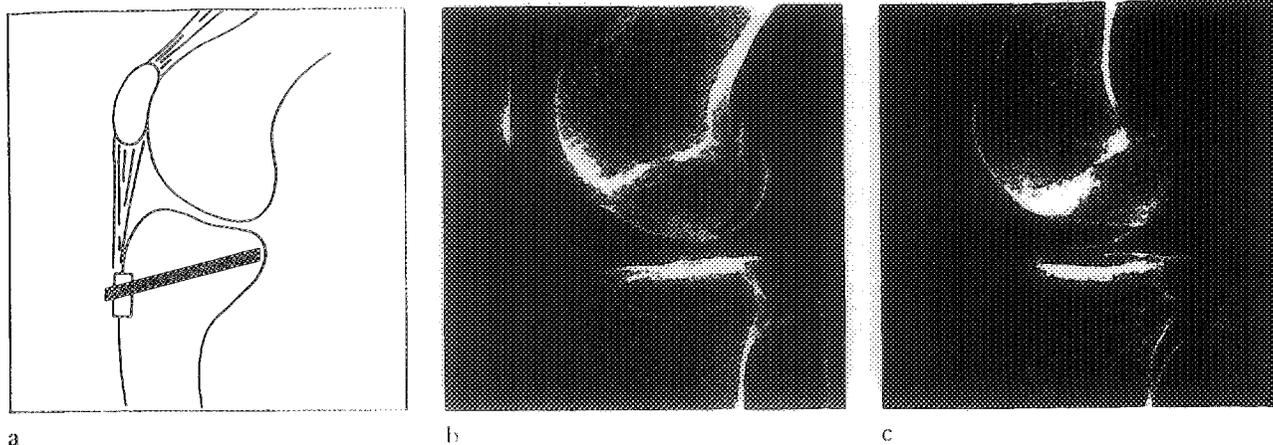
Hauser's operation for recurrent patellar dislocation. Fixation of the block of the patellar tendon insertion (a). Radiograph of the knee seen preoperatively (b) and one year postoperatively (c). The block of the patellar tendon insertion was fixed with one 4.5 by 70 mm BIOFIX®-rod.
